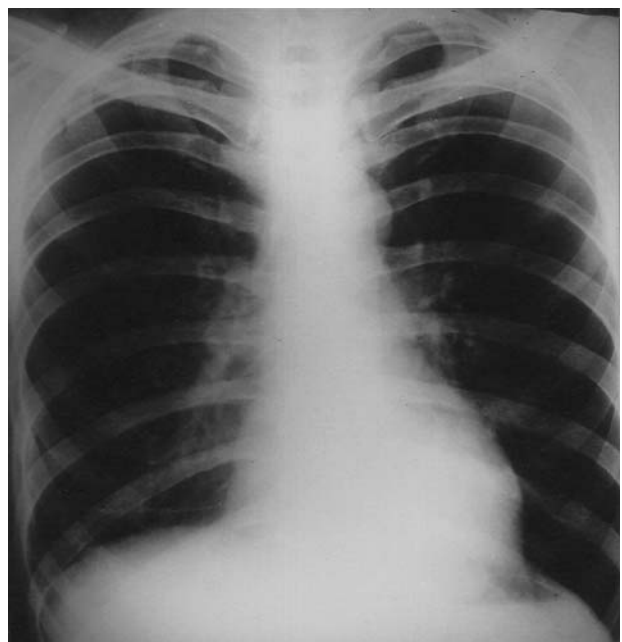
Chest radiograph (postero-anterior view) obtained four weeks later showing resolution of haematoma.
